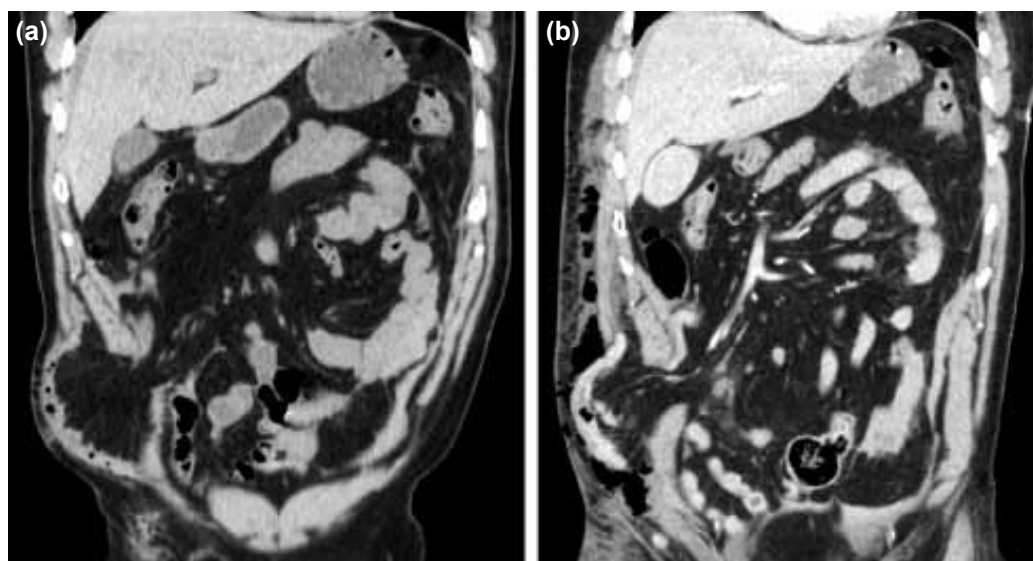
(a) Coronal CT scan upon admittance, showing haemoperitoneum in left abdomen and uncomplicated TAWH with small bowel loop. (b) Coronal CT three hours after ICU admission with important subcutaneous and intramuscular emphysema in the right flank and bowel wall thickening in the hernia, suggesting a bowel perforation.
